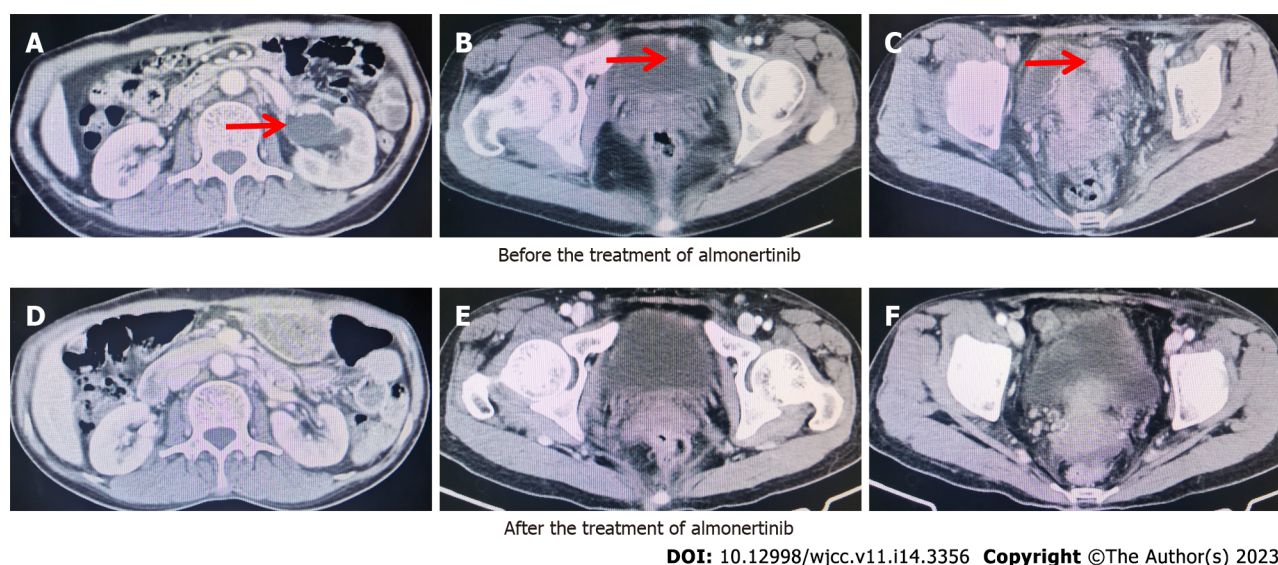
Computed tomography images recorded tumor regression of bladder metastasis after almonertinib therapy. A-C: Before treatment; D-F: After treatment.
